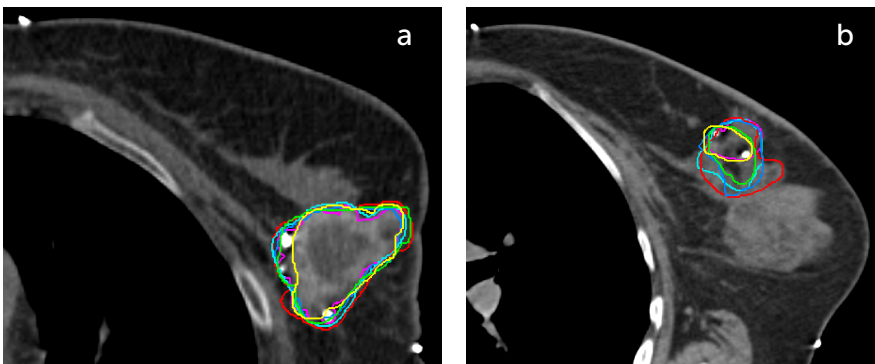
and 1b Example of tumor bed delineation on CT with (a) and without (b) hydrogel.
